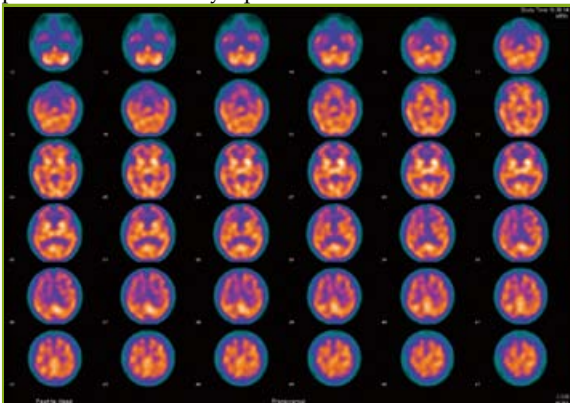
Single-Photon Emission Computed Tomography (SPECT) brain perfusion scan of Ms A showing typical frontal-temporal perfusion deficits of FTD (1: Transverse view)
